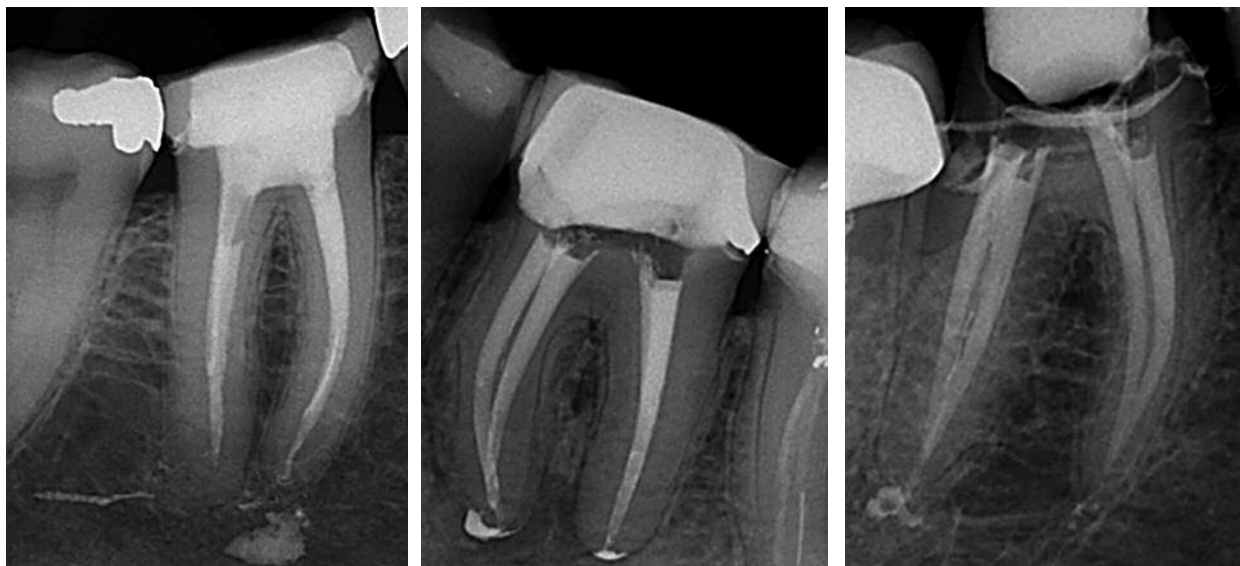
In this case, SAF was used up to working length and upon obturation it resulted in severe cement overfill into the periapical tissues.
